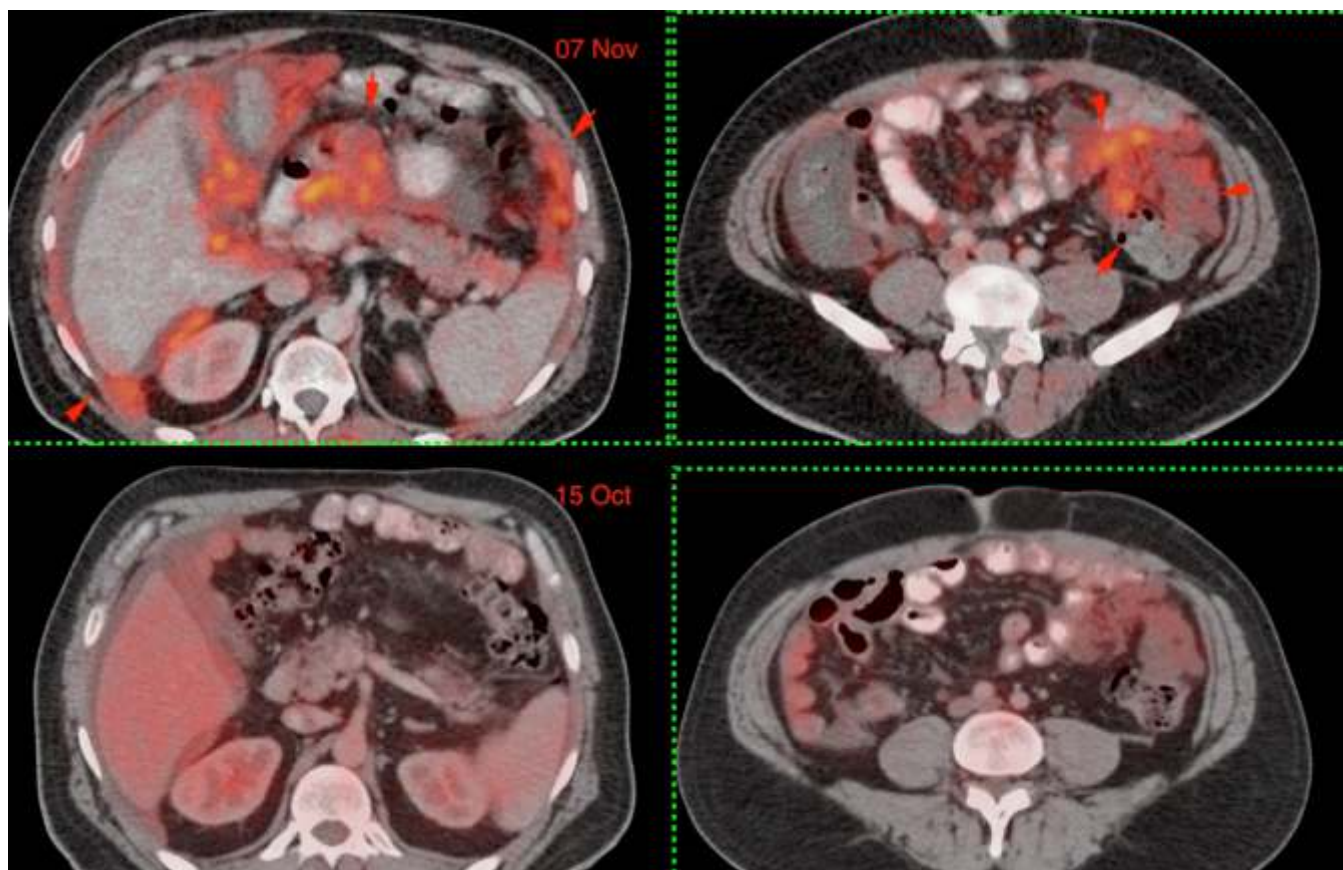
53-yrs old man with peritoneal spread from an operated descending colon carcinoma. He presented with ascites 3 years later. An FDG PET/CT (lower panel) showed ascites and peritoneal spread. However, the uptake of the lesions was low and the exact disease burden was difficult to estimate. A FAPI PET/CT done 3 weeks later (upper panel) showed how widespread the disease was with extensive omental and peritoneal nodules and masses. In this case, FAPI PET/CT helped us understand the extent of disease, which in turn helped with treatment planning and served as a baseline for future follow-up
